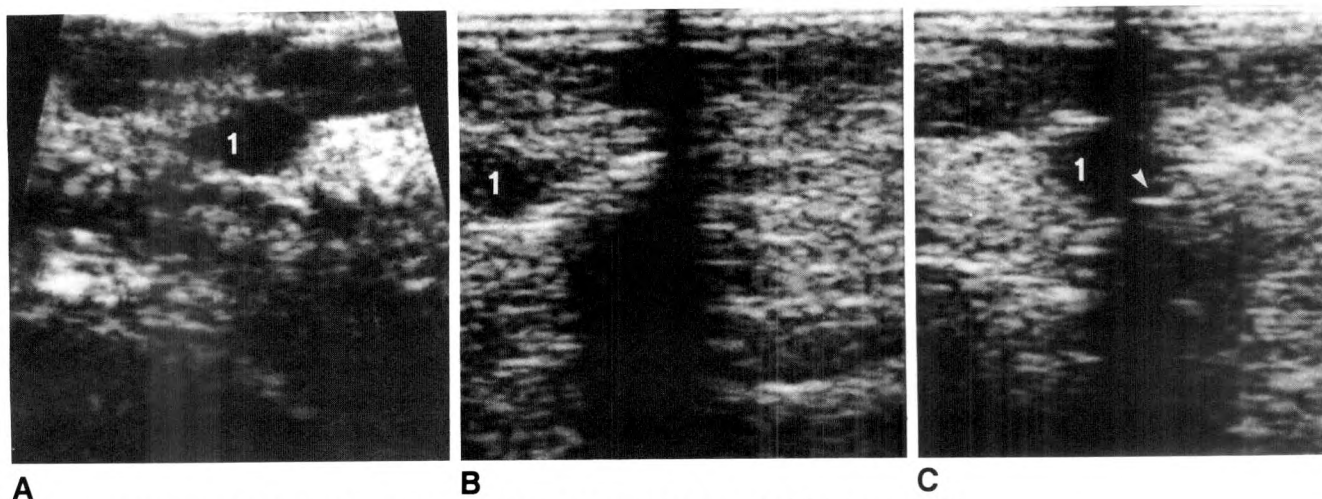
Sonograms of the breast showing a 1×0.6 cm hypoechoic nodule due to medullary carcinoma (1).
